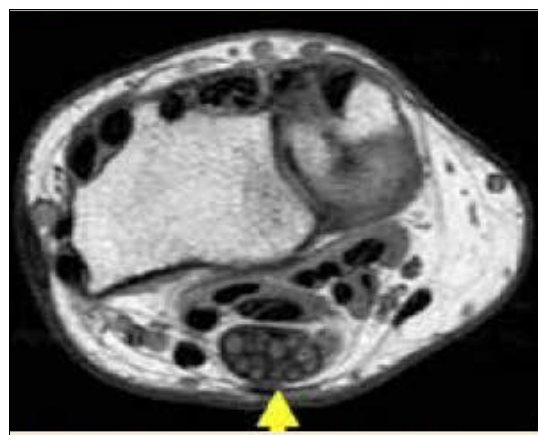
Axial T1-weighted imaging of the wrist through Guyon’s canal which is grossly distended with fat (arrow head) and thickened fascicles of the ulnar nerve. The patient presented with paresthesia in the ulnar nerve distribution. EMG confirmed conduction delay.
